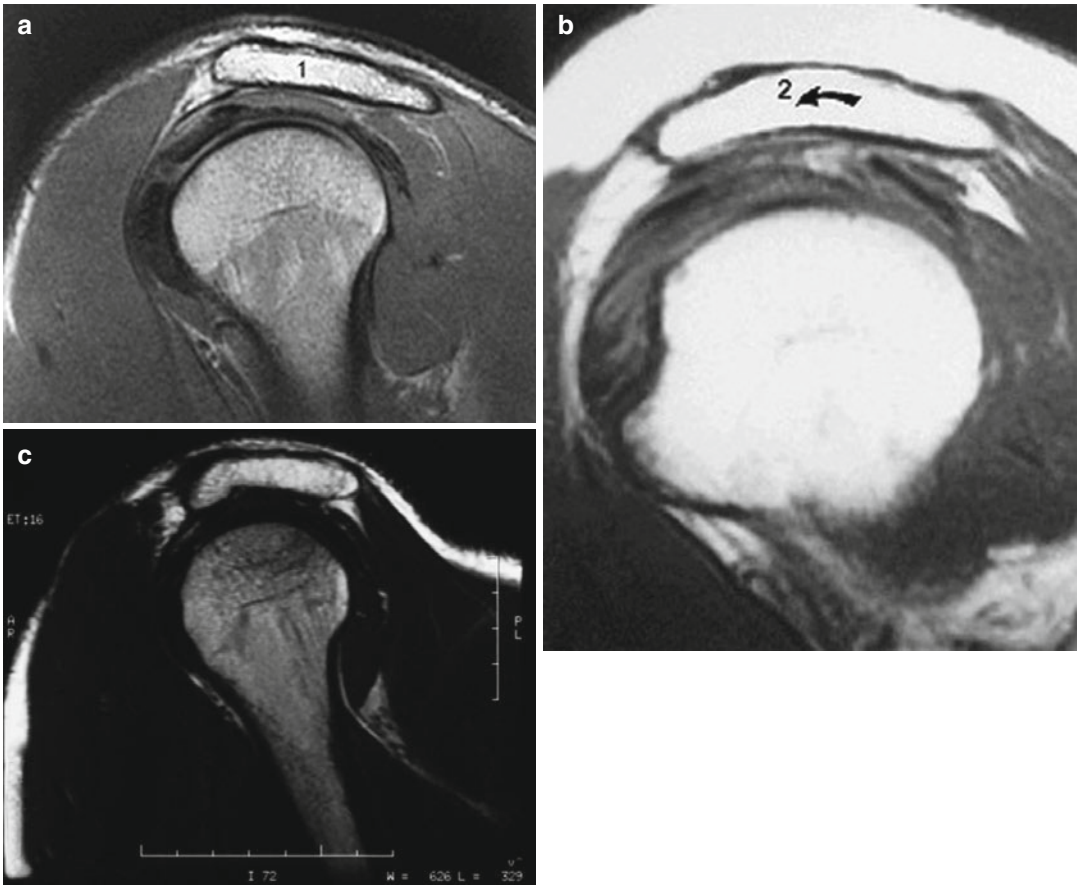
MRI evaluation of acromial morphology. (a) Type I, flat. (b) Type II, curved. (c) Type III, hooked. Copyright Kevin D. Plancher
